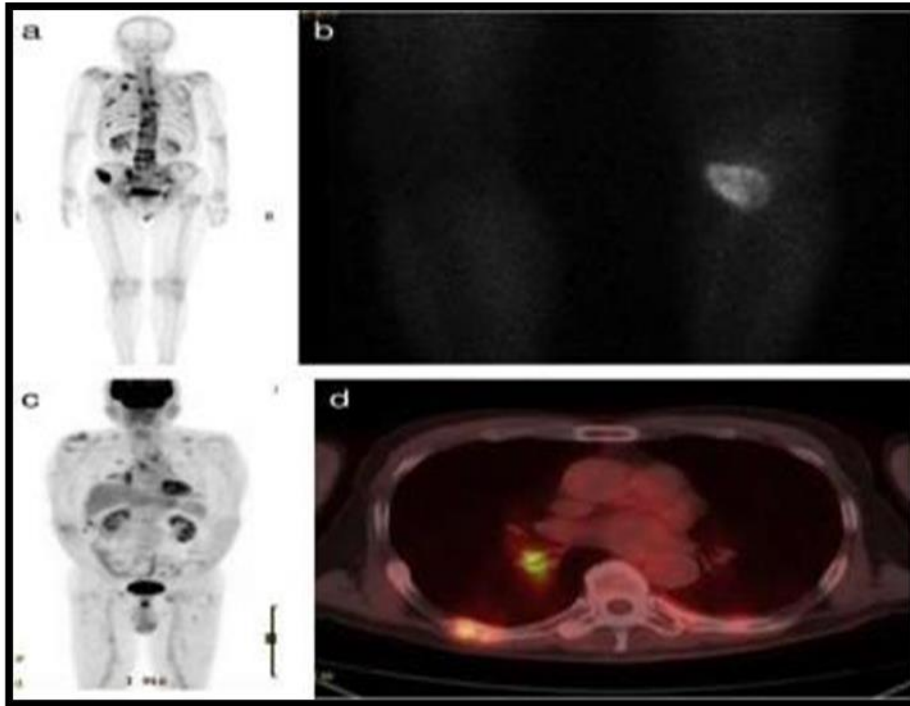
Nuclear scintigraphy; a. Bone scintigraphy, b. ^{201}Tl scintigraphy. Osteosarcoma of distal femur, c. Multiple metastases of angiosarcoma, d. PET-CT. Metastatic tumor of rib (Miwa et al., 2013).
